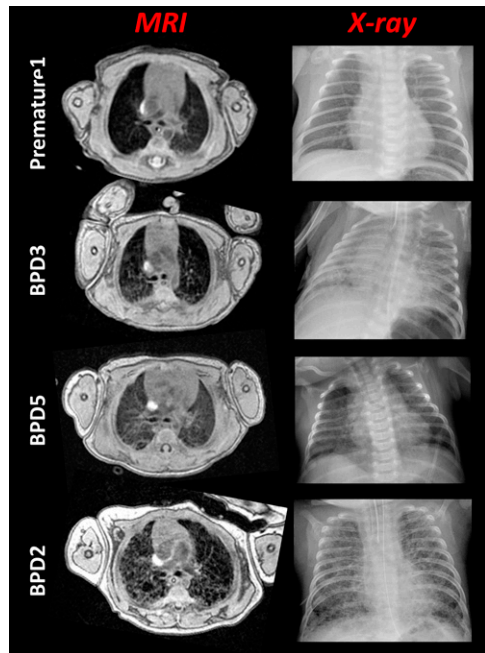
Phenotyping lung disease in neonates with quantitative magnetic resonance imaging (MRI). For each patient, an axial fast gradient echo slice (taken near the carina) is compared with a clinical chest radiograph. Notice the vastly differing parenchymal structure in each of the patients. Day of chest radiograph (MRI date as Day 0): Premature1 (Day -5), BPD3 (Day -17), BPD5 (Day -2), and BPD2 (Day +2). The radiologic scores for the MRIs were 2, 10, 5, and 14 for Premature1, BPD3, BPD5, and BPD2, respectively, using the system in Table 2. BPD = bronchopulmonary dysplasia.
